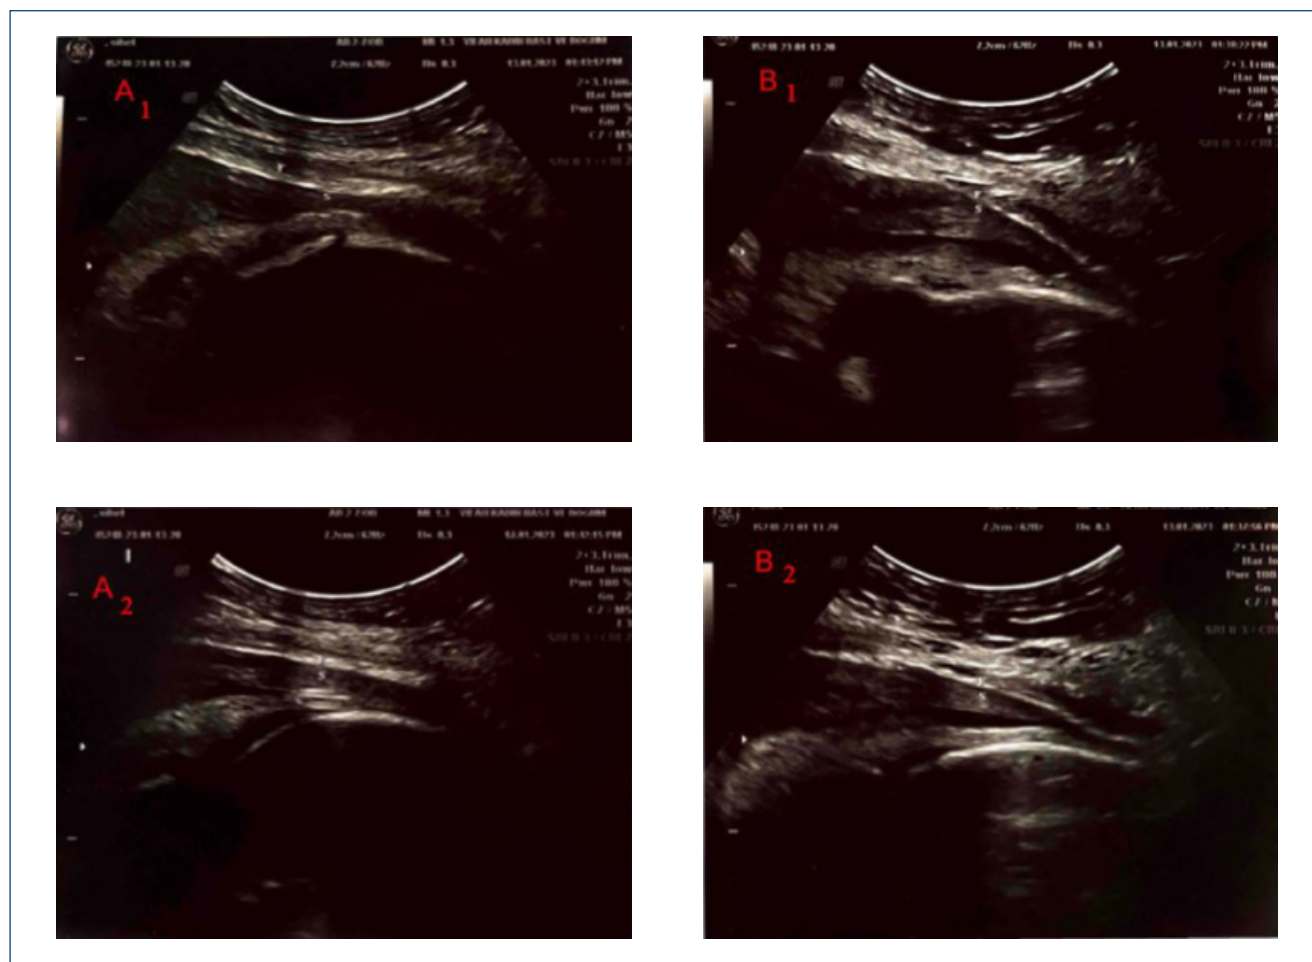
Transabdominal ultrasound images showing the presence or absence of “sliding sign.” Top images before deep breath (A1,B1), bottom images after deep breath (A2,B2). “S” represents uterine serosa and “F” represents muscle fascia. (A2) After deep breath uterine serosa sliding caudally under the fascia transversalis (positive sliding sign). (B2) No movement of the uterus under the fascia transversalis was noted (negative sliding sign).
